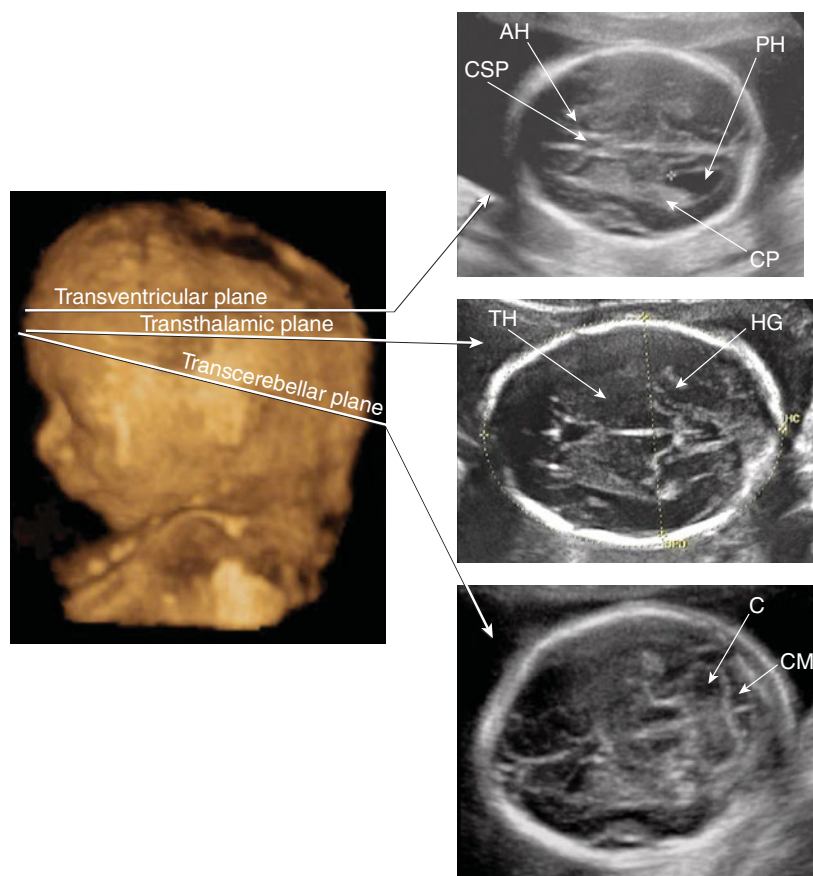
The basic brain scan is performed by transabdominal sonography and its objective is to evaluate the fetal brain only in the general axial (horizontal) planes. It includes three planes: transventricular, transthalamic, and transcerebellar.
